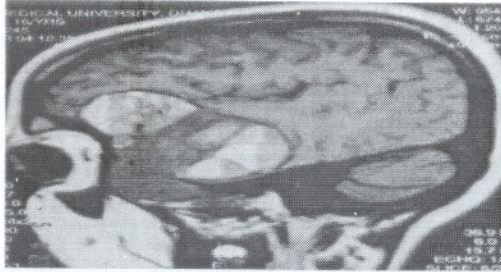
Pre and post contrast parasagittal MR images of brain shows heterogeneous strong enhancement of the lesion.
